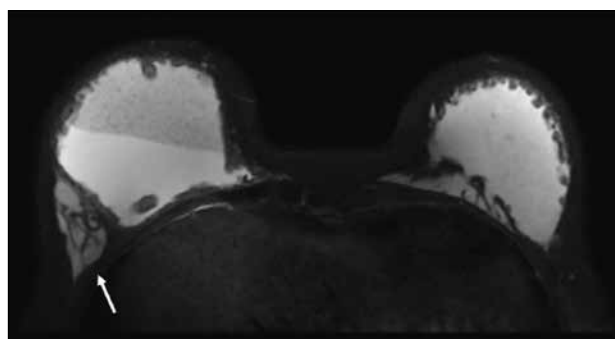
A patient with bilateral polyacrylamide hydrogel (PAAG) augmentation. T2-weighted fat-saturated axial magnetic resonance imaging showing a multi-loculated T2-weighted hyperintense collection (arrow) in the lower outer quadrant of the right breast, outside the expected location of the PAAG collection, suggesting migration of PAAG materials.
